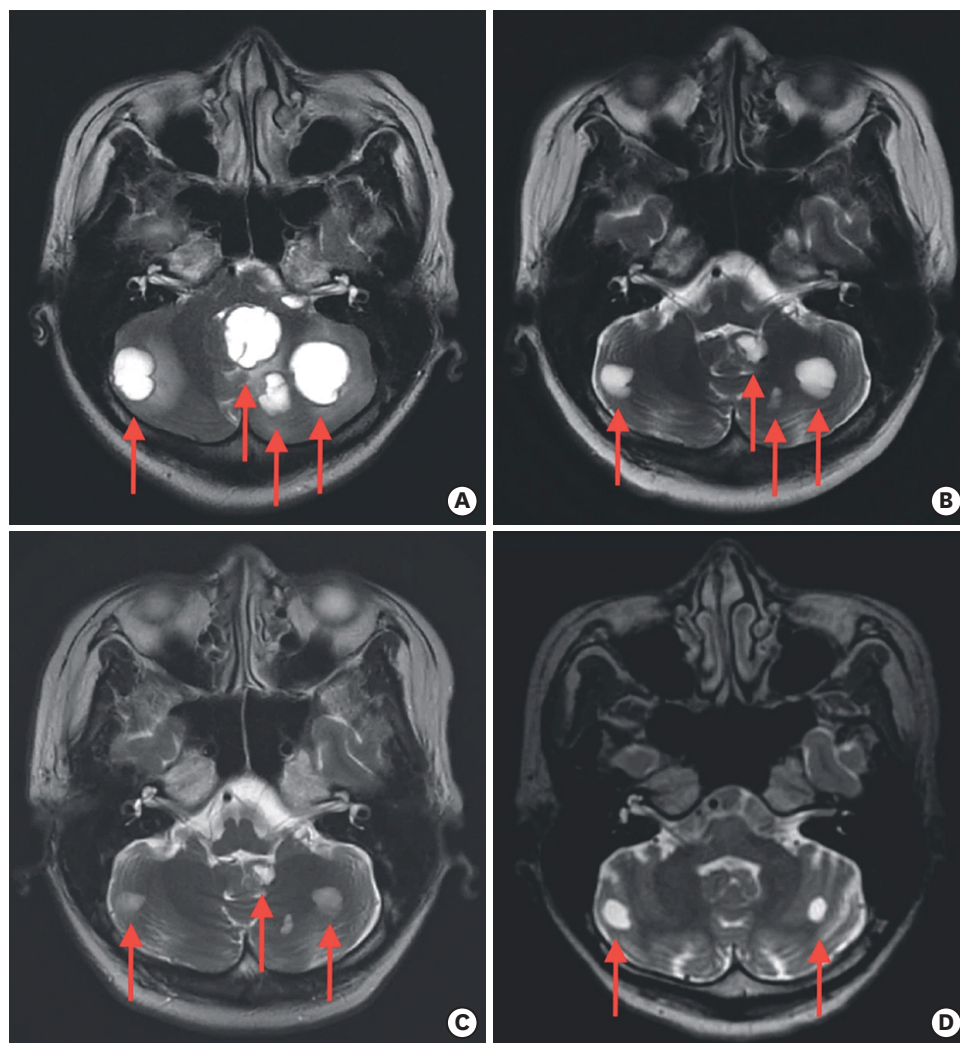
Axial T2-weighted MR image at the pons level. (A) Pre-radiosurgical MR image before IVIG therapy and WBRT; (B) 2 months after IVIG therapy and WBRT; (C) 7 months after IVIG therapy and WBRT indicated the larger metastatic lesions in the bilateral cerebellar hemispheres exhibited regression in size; (D) 28 months after IVIG therapy and WBRT indicated no interval change. The red arrows indicated the metastatic brain lesions. MR = magnetic resonance; IVIG = intravenous immunoglobulin; WBRT = whole brain radiotherapy.
